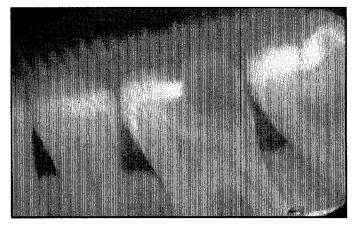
Year 10. Obviously darker and larger compared to year 9 radiograph
